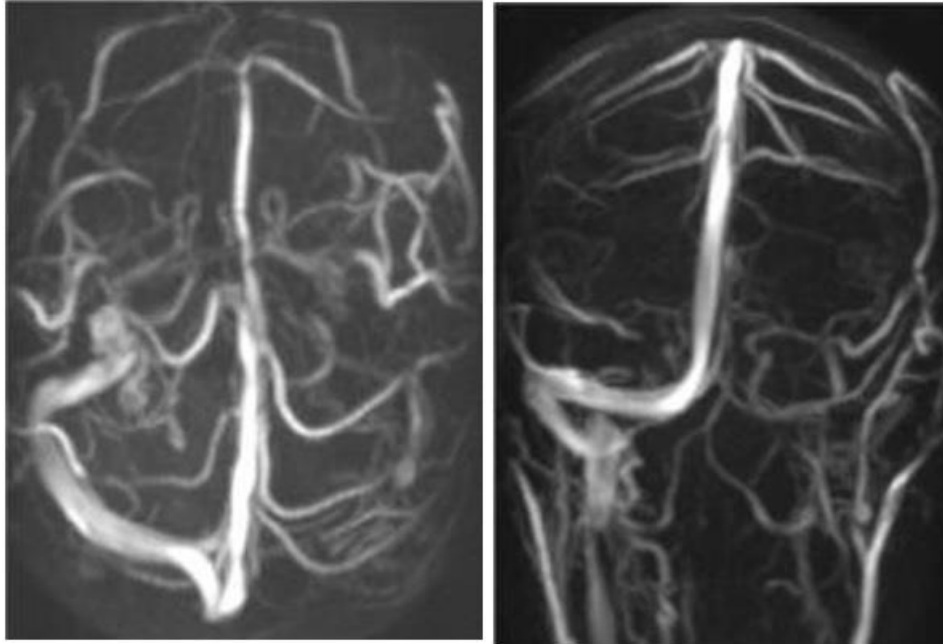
Person 3, Angio MRI showed asymmetry of the intracranial venous circulation, with prevalence of flow at right.
